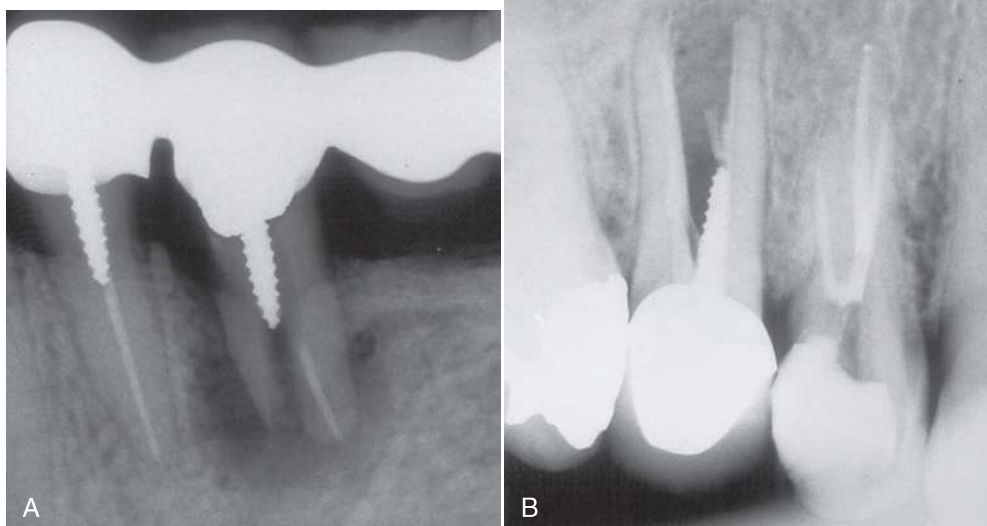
Radiographs of longstanding vertical root fractures. No special diagnostic skills are needed to diagnose such cases.
